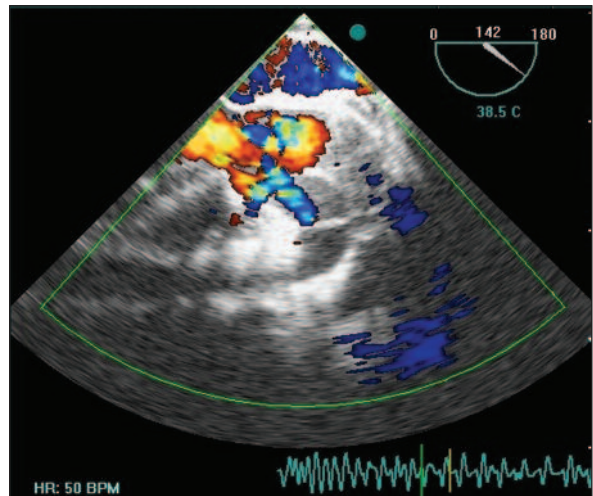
Transoesophageal echocardiography color Doppler showed flow codes at the site of the intimal tear.
